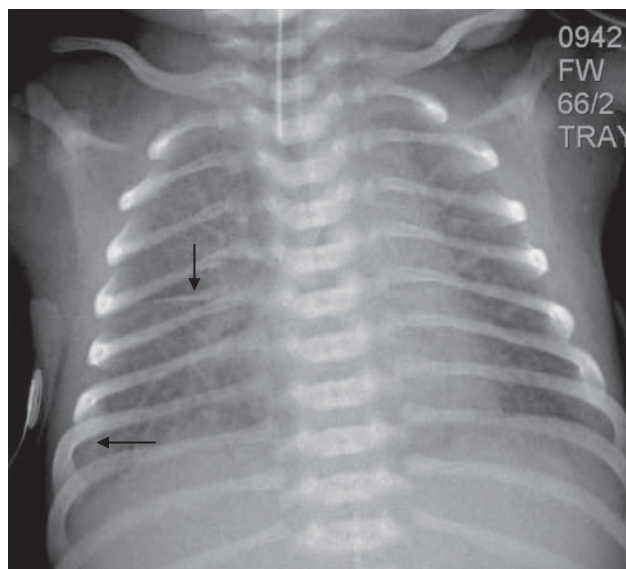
Frontal radiograph of the chest in a patient with obstructed total anomalous venous return shows increased indistinctness of the pulmonary vessels from diffuse pulmonary edema and fluid seen in the right costophrenic angle and horizontal fissure (black arrows).
